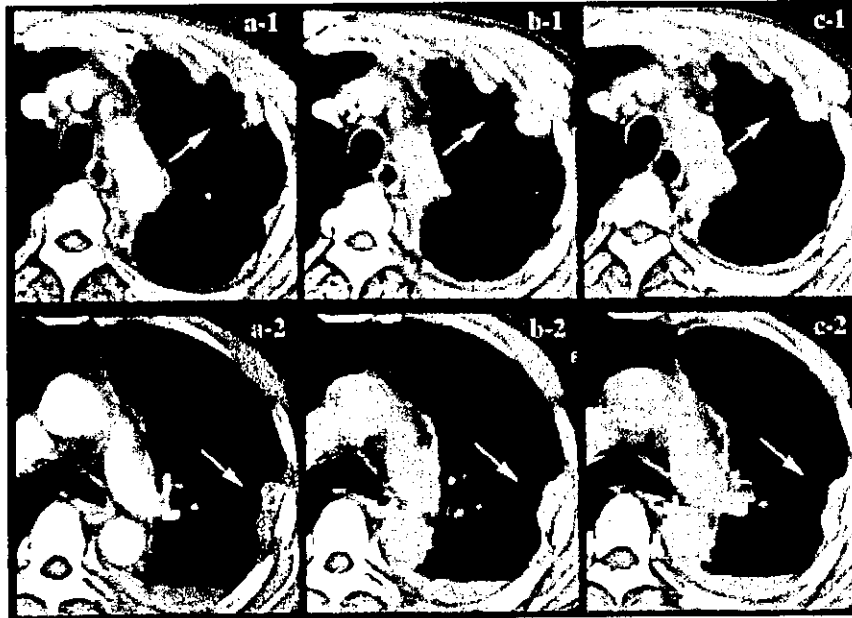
CT images of the EBL-002 patient. (a) After the 1st vaccination. (b) After the 4th vaccination, the pleural dissemination was increased. (c) After the 8th vaccination, a regression of the pleural dissemination was observed.
